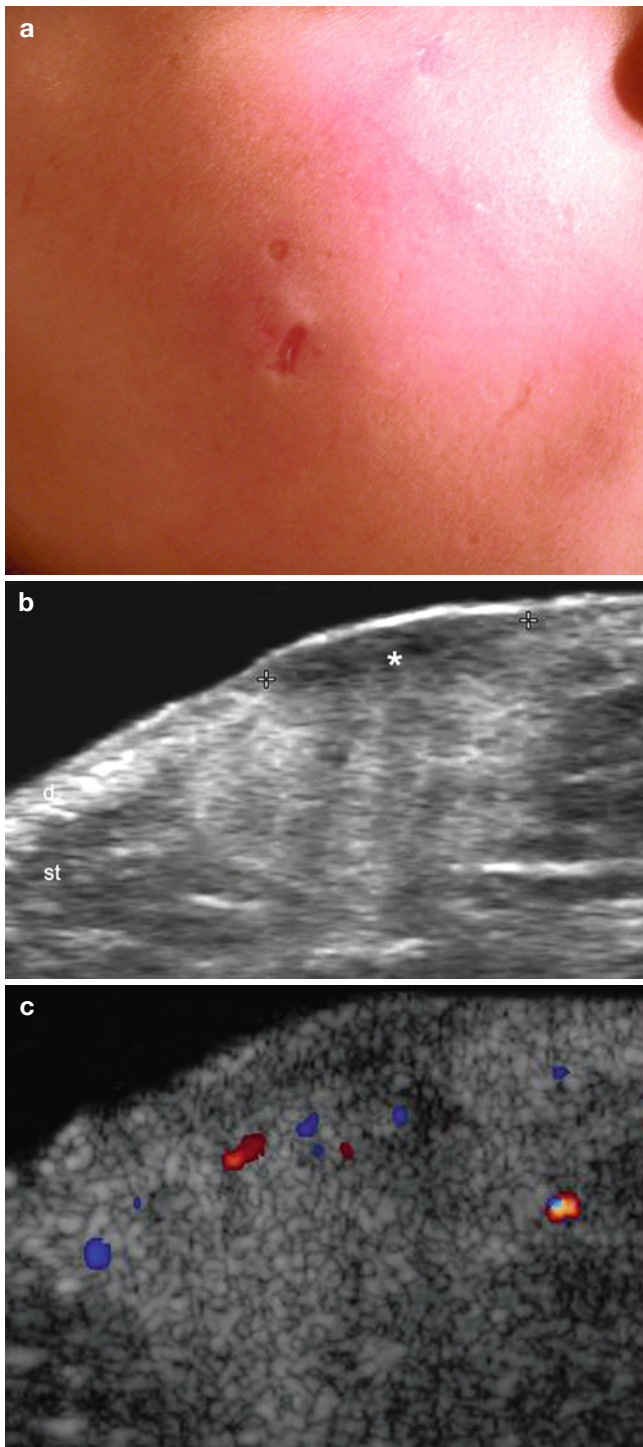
(a–c) Cutaneous lupus (active phase). (a) Clinical image with erythema and swelling in the right cheek. (b) Gray scale ultrasound image (transverse view) shows fusiform shaped decreased echogenicity and thickening of the dermis (*) as well as increased echogenicity of the subcutaneous tissue. (c) Color Doppler ultrasound image (transverse view) demonstrates increased vascularity in the lesion site. *Abbreviations: d* dermis, *st* subcutaneous tissue
